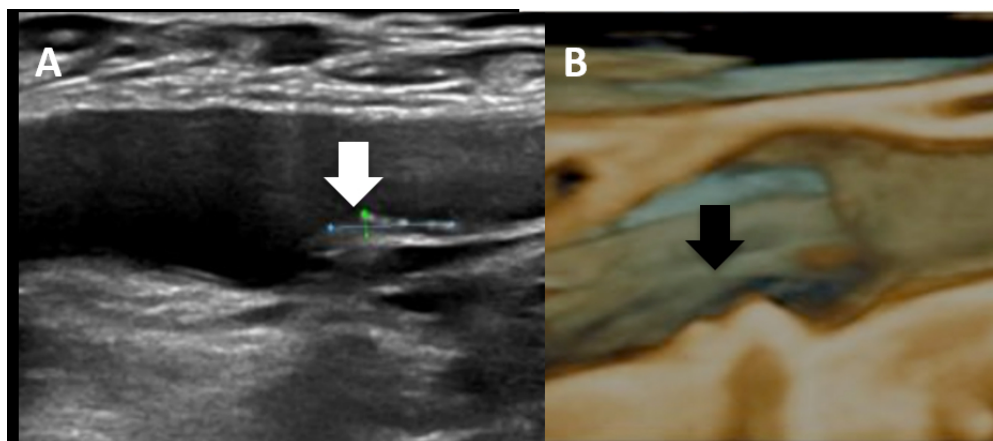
2D vascular ultrasound of atherosclerotic plaque (white arrow) in the right femoral artery and (A) and 3D vascular ultrasound of another atherosclerotic plaque (black arrow).
